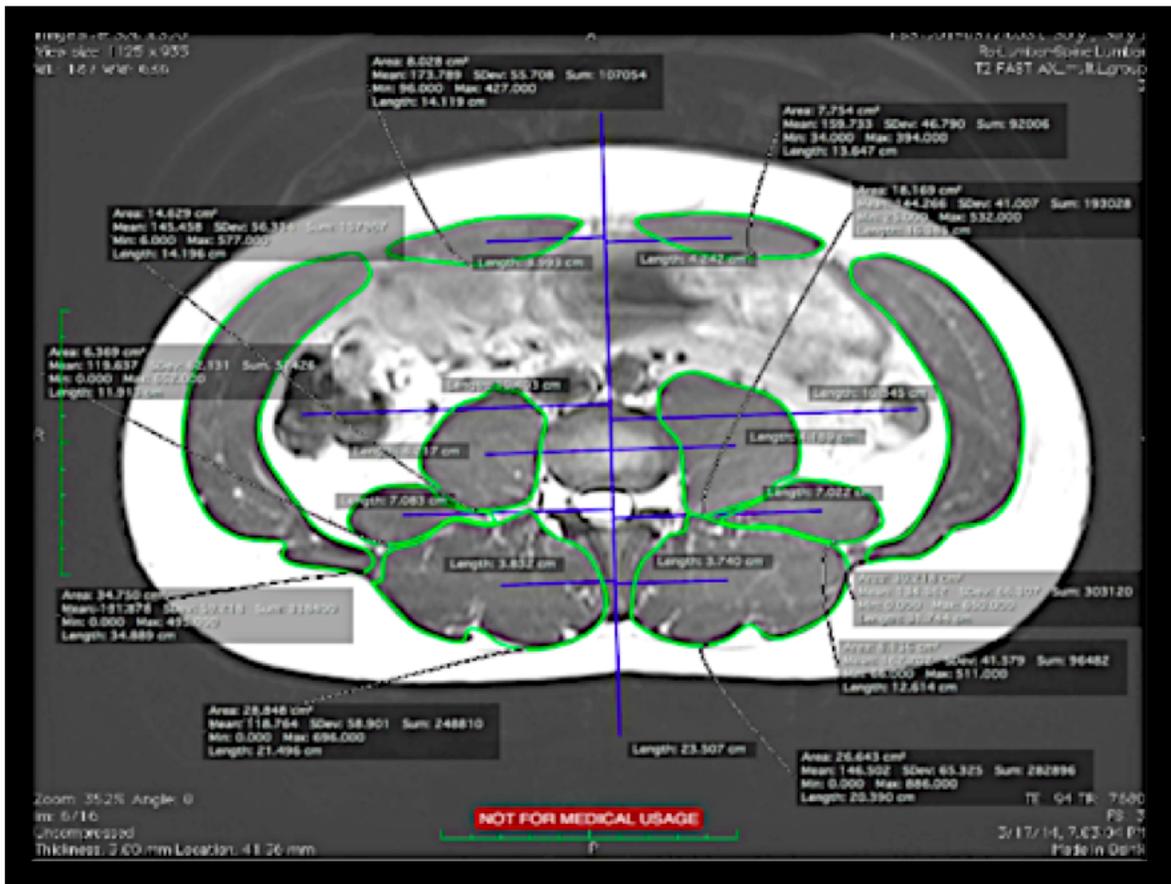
Example of an MRI scan processed using architectural design and tracing software
